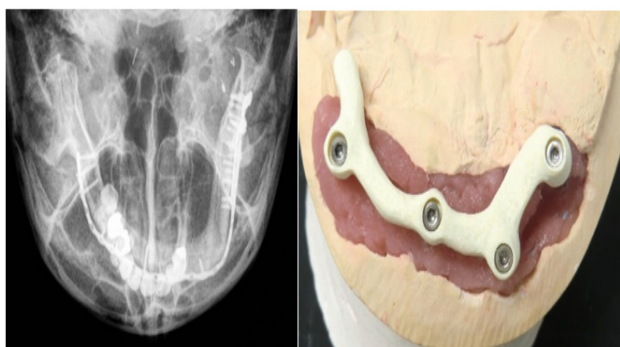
Panoramic radiograph of the CAD/CAM produced TRINIA prosthesis at initial loading after screw-retained fixation with Hex Retention Screws on Fixed-Detachable Abutments using 2.5 mm Posts.
